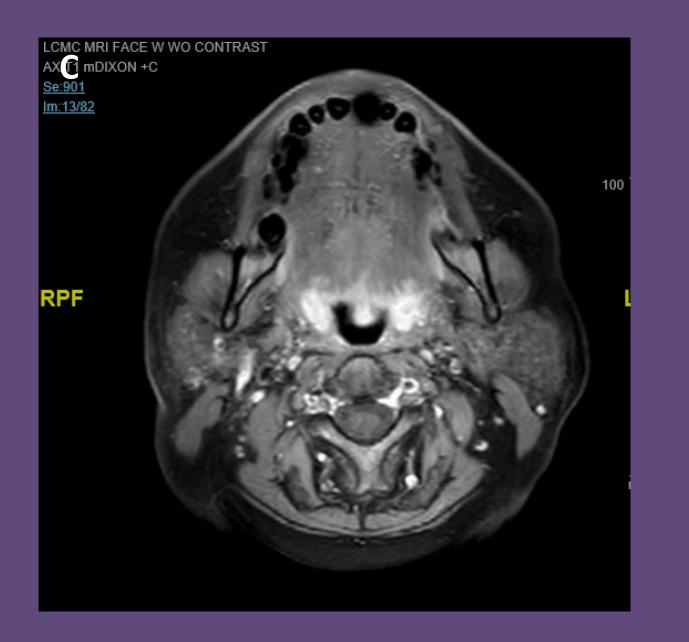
Coronal T2 Neck MRI. An intraparotid lymph node nonenhancement consistent with necrosis.
